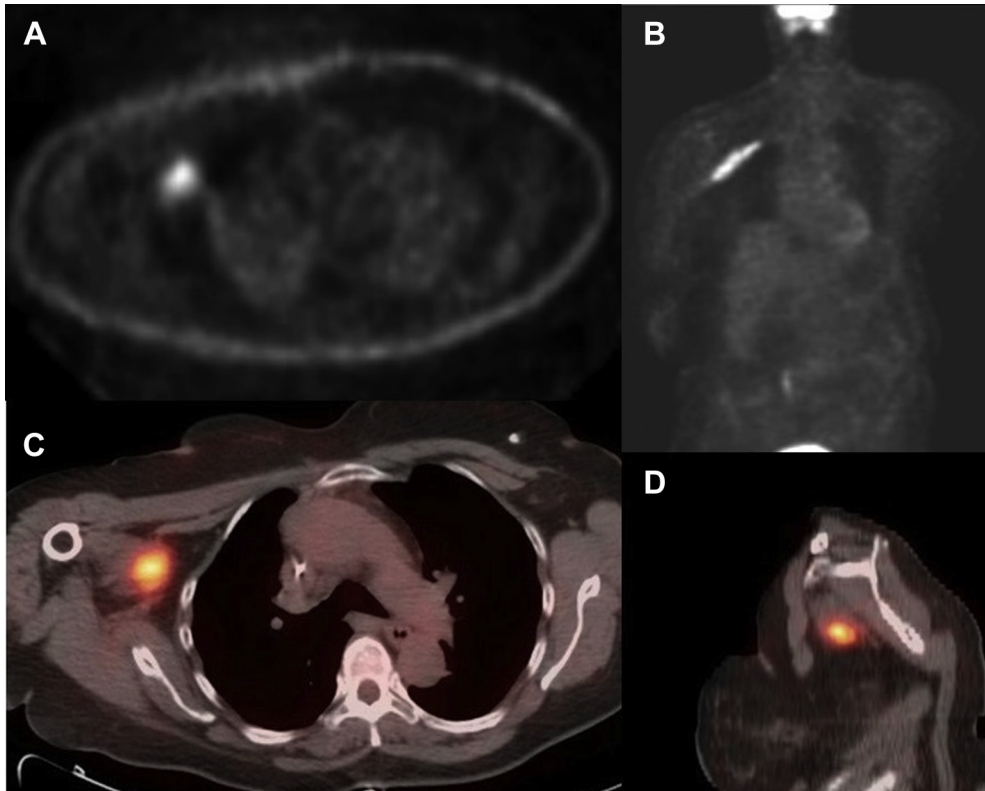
The axial nonattenuated corrected (A), coronal attenuated corrected (B), axial fused positron emission tomography-computed tomography (PET-CT) (C), and sagittal fused PET-CT (D) images demonstrated a very hypermetabolic mass involving the right brachial plexus.
